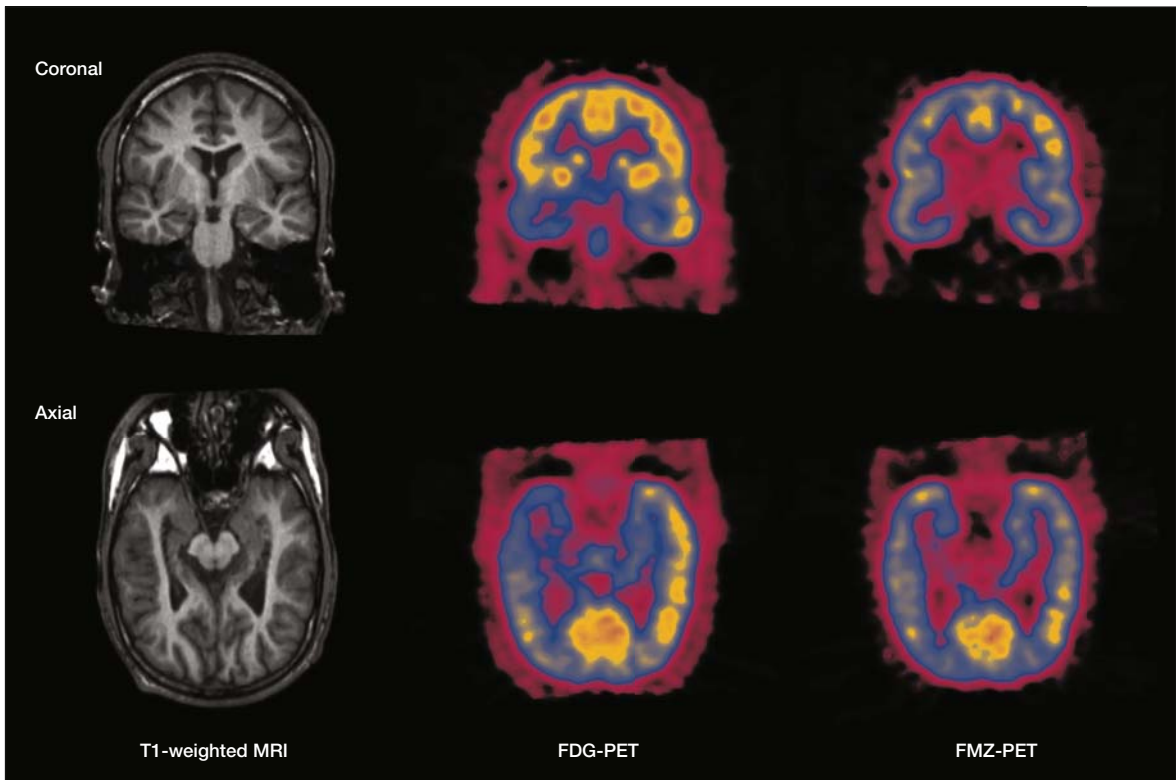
FDG-PET and FMZ-PET images were co-registered with a T1-weighted MRI scan. The T1-weighted MRI scan demonstrates hippocampal atrophy on the right. FDG uptake is reduced in the corresponding region extending to the ipsilateral lateral temporal cortex and parietal area. In contrast, the reduction in GABA_A receptor binding is fairly restricted within the right mesial temporal lobe structures.
